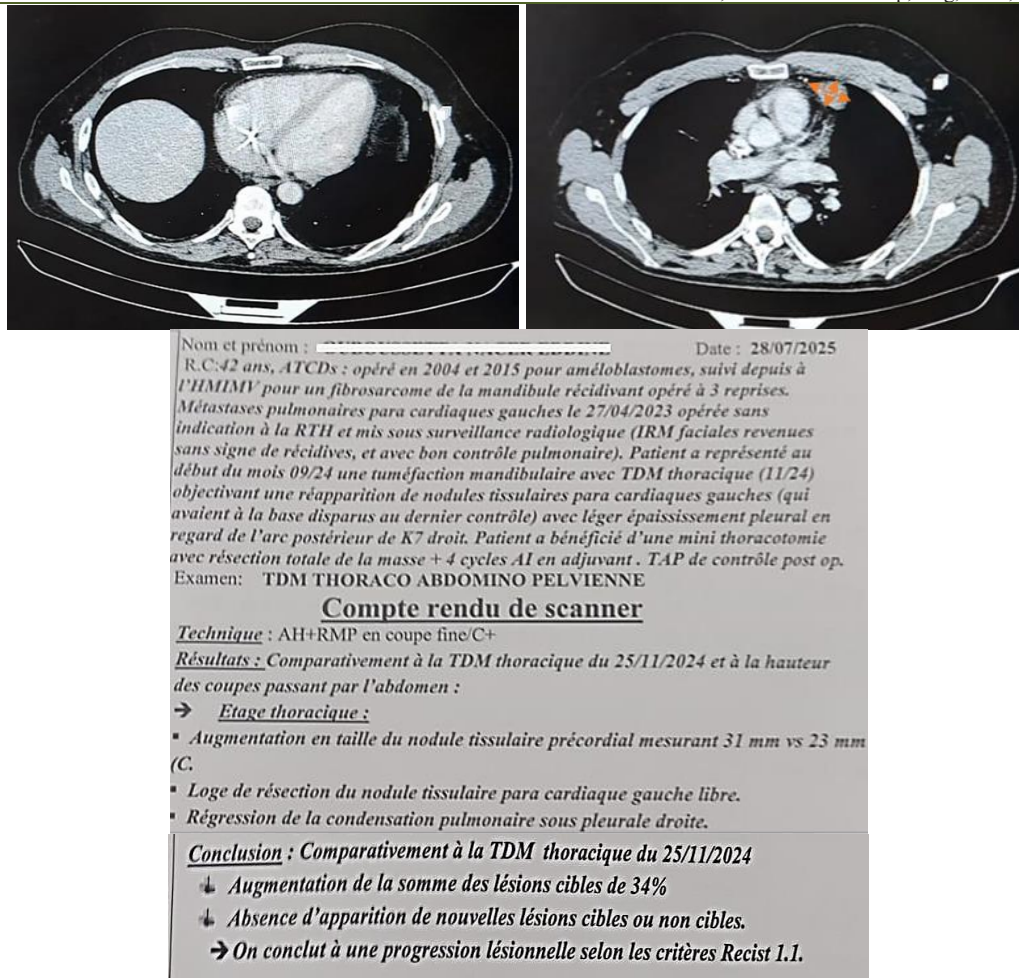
Images and report of chest CT scan showing good local control of the paracardiac mass and the appearance of the precordial mass
